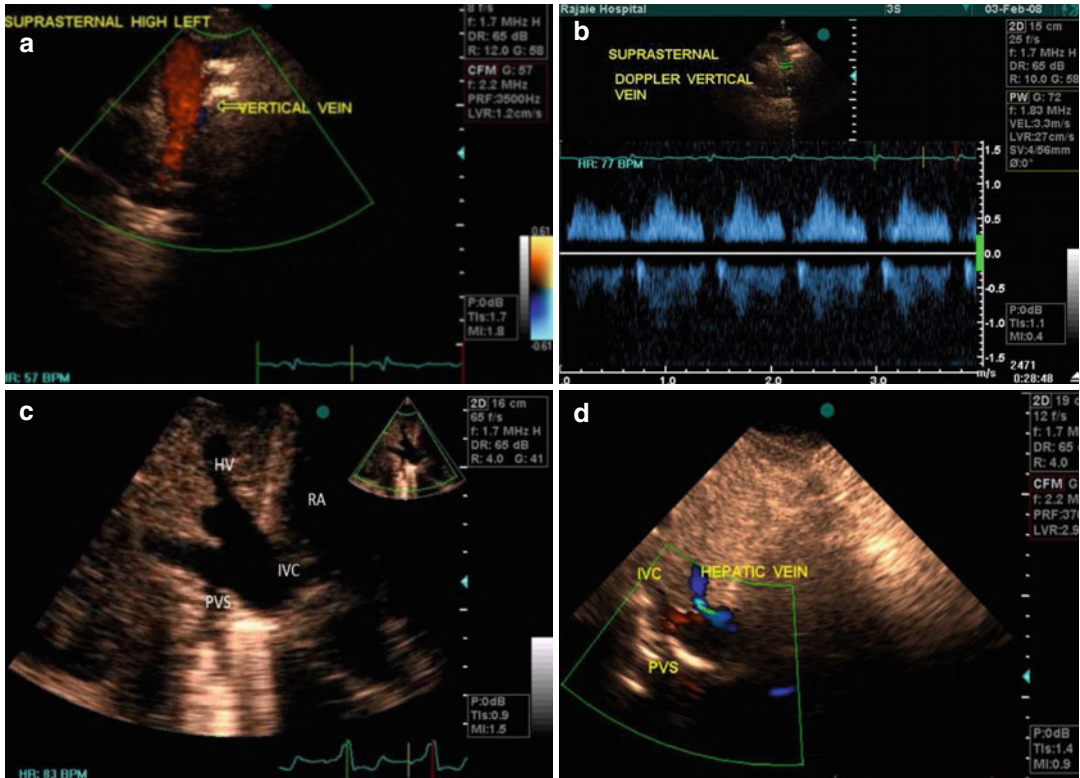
(a, b) Transthoracic echocardiographic evaluation of PAPVC in the suprasternal view demonstrating a vessel parallel to the aortic arch with red color flow suggestive for vertical vein as it is connecting the left pulmonary veins to the innominate vein and then to the SVC.
